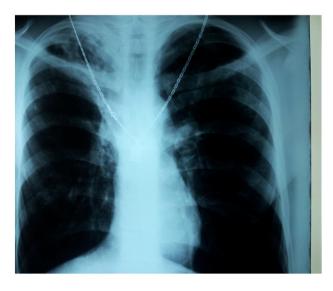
Chest X-ray showing expanded interstitium with signs of mild emphysema, hyperinflation and fibrosis.
